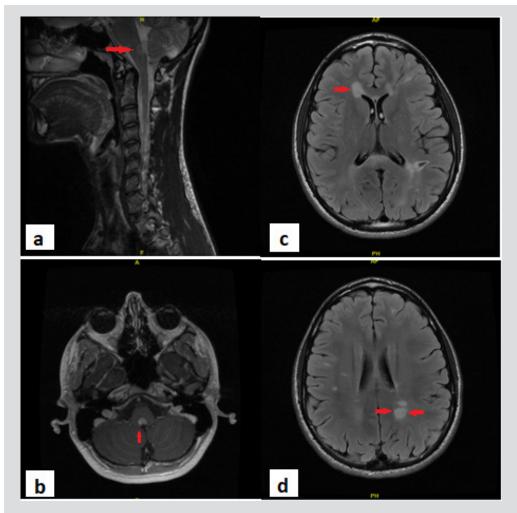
Brain MRI at time of presentation. (a)
